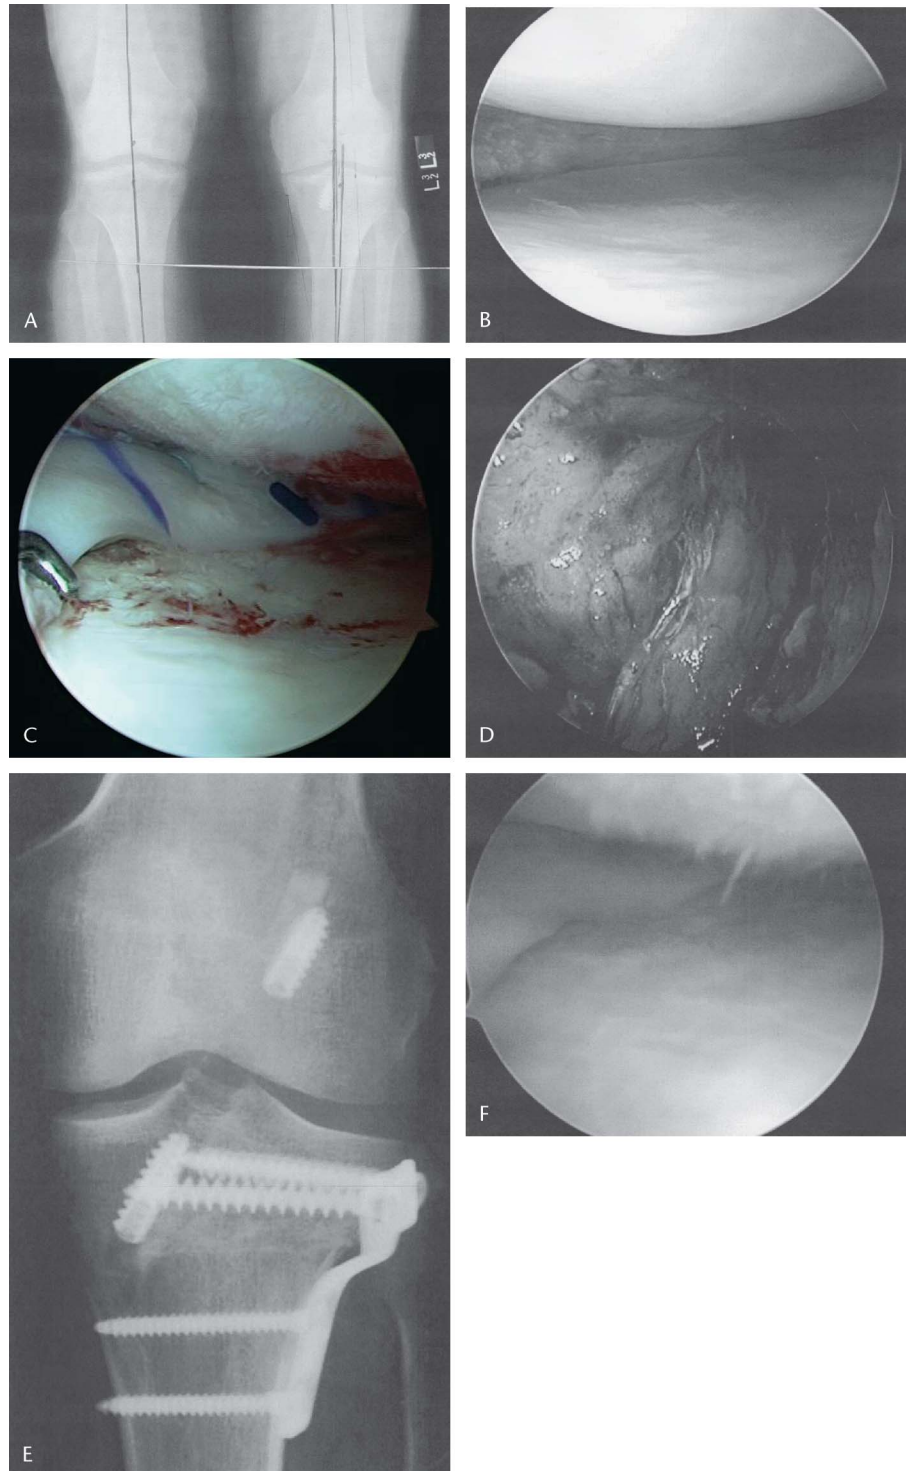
Case example of a 32-year-old man who underwent an ACL reconstruction with a BTB autograft and a complete medial meniscectomy. He presented nearly 5 years later with the onset of significant instability and medial joint line pain with a varus deformity. At revision surgery, he had (A) an anteroposterior weightbearing radiograph demonstrating varus alignment. At arthroscopy, he had (B) an absent medial meniscus with minimal articular cartilage damage along the posterior aspect of the medial femoral condyle and an attenuated ACL graft. He underwent (C) a medial meniscus transplant and (D) an ACL revision with a BTB allograft combined with (E) a closing wedge high tibial osteotomy. At 2 years postoperatively, a second look arthroscopy performed at the time of hardware removal demonstrated (F) excellent healing of his meniscus and ACL with no significant progression of his articular cartilage wear.
